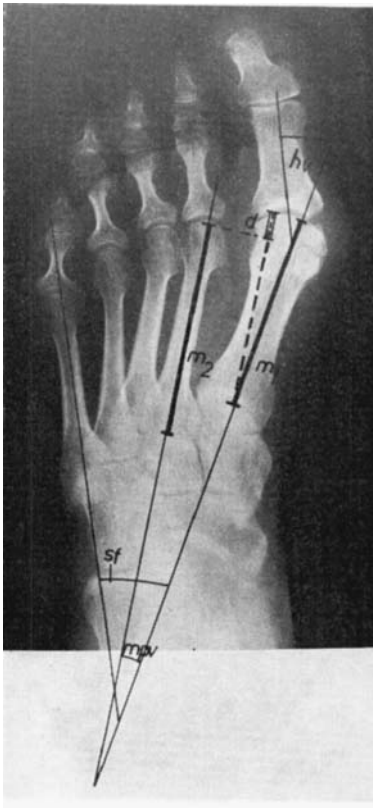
Standard radiograph with actual parameters:
